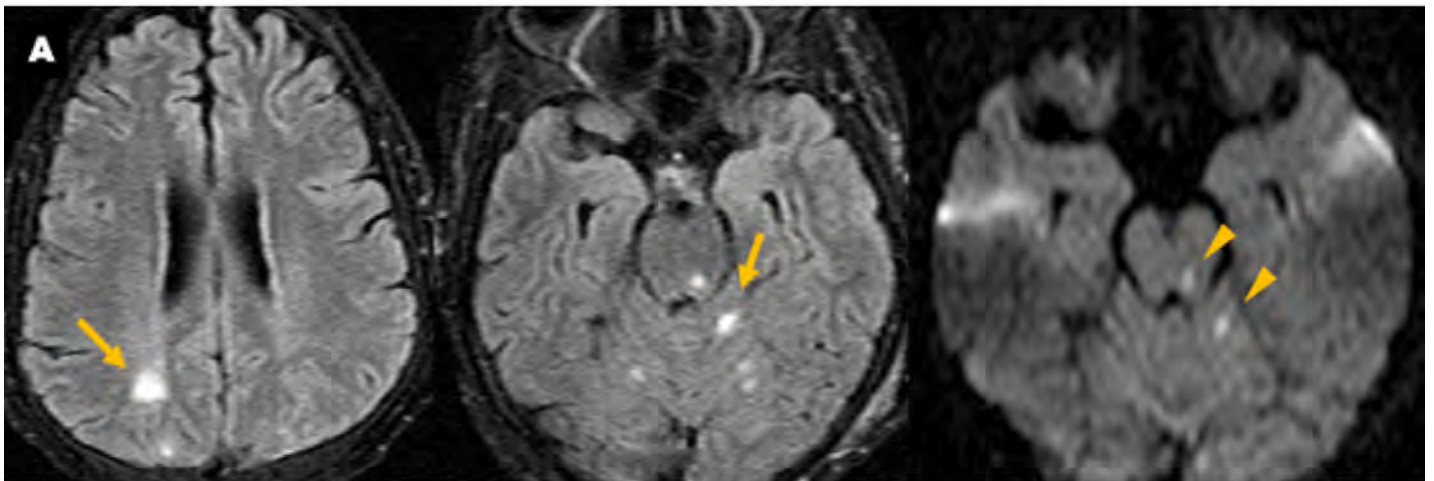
Invasive fungal (*Malassezia*) CNS infection in a 15-year-old with a history of orthotopic heart transplant. Axial FLAIR and DWI.
